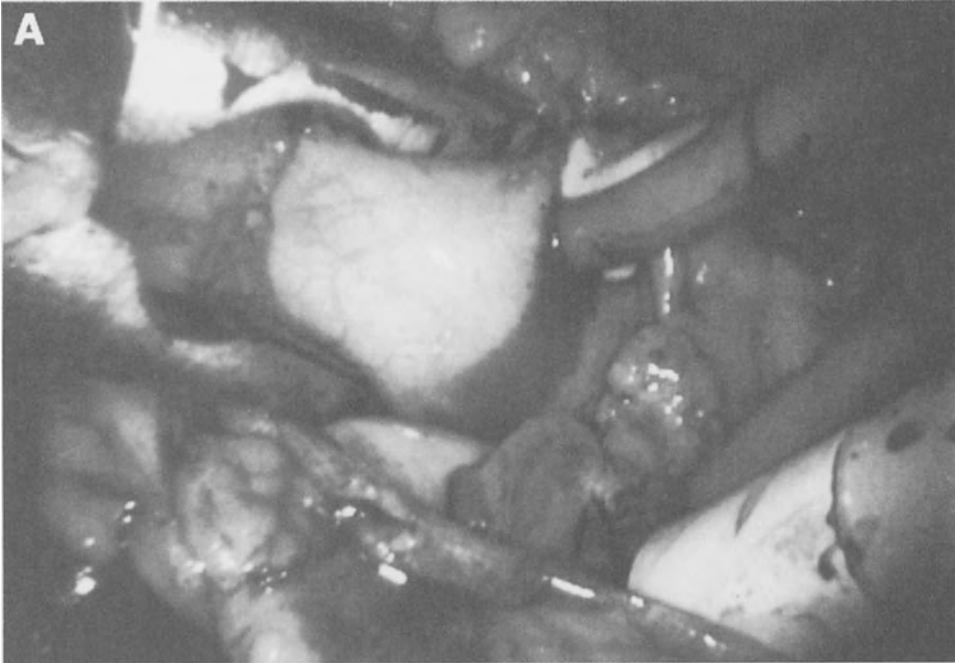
Transthoracic aortic occlusion. (A) Intraoperative photograph depicts the transthoracic clamp jaws being positioned around the aorta. The posterior jaw is positioned, using video assistance, through the transverse sinus. Care must be taken to avoid injury to the right pulmonary artery and to assure total aortic occlusion. (B) The clamp has been closed and antegrade cardioplegia is being administered via the aorta. The venous cannula can be seen in the lower right foreground.
